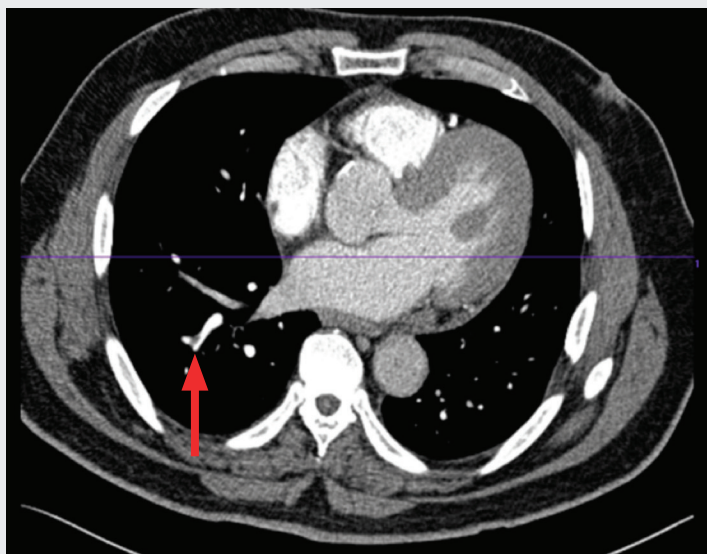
Enhanced computed tomography (axial view) of the chest showing small filling defect in the sub segmental branches of the right lower lobe (arrow).
